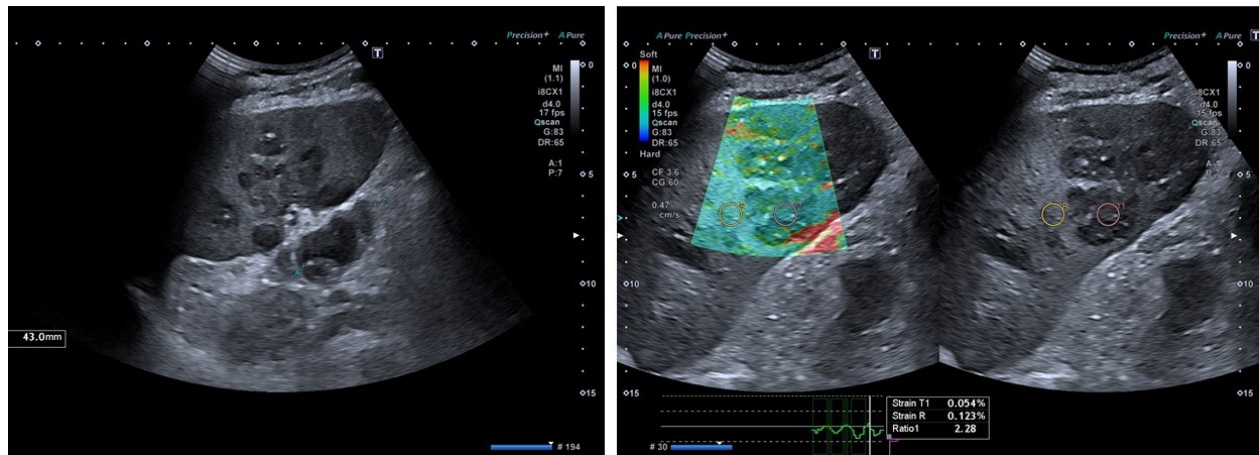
b.6. Malignant splenic lymphoma. B mode ultrasound demonstrates hypoechoic solid foci within the spleen and lymphadenopathy in the splenic hilum (left panel). Real time elastography demonstrates increased stiffness of the lymphoma in comparison to the surrounding splenic parenchyma (Strain ratio 2.28, right panel)
